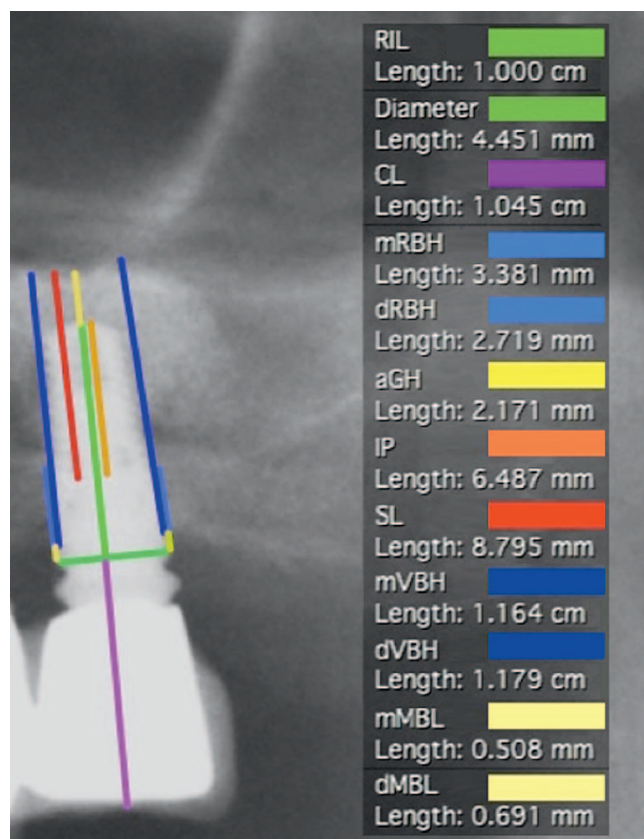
Example of radiographic measures at T1 and T2 on orthopantomography. Green: radiographic implant length (RIL) and diameter. Light blue: height of residual bone at the mesial (mHRB) and distal (dHRB) aspects of the implant. Yellow: height of the graft apically (aGH). Orange: implant penetration (IP). Red: extent of the sinus lift (SL). Light yellow: marginal bone level at the mesial (mMBL) and distal (dMBL) aspects of the implant. Dark blue: vertical bone height at the mesial (mVBH) and the distal (dVBH) aspects of the implants. Purple: crown-to-implant ratio (C/I).
